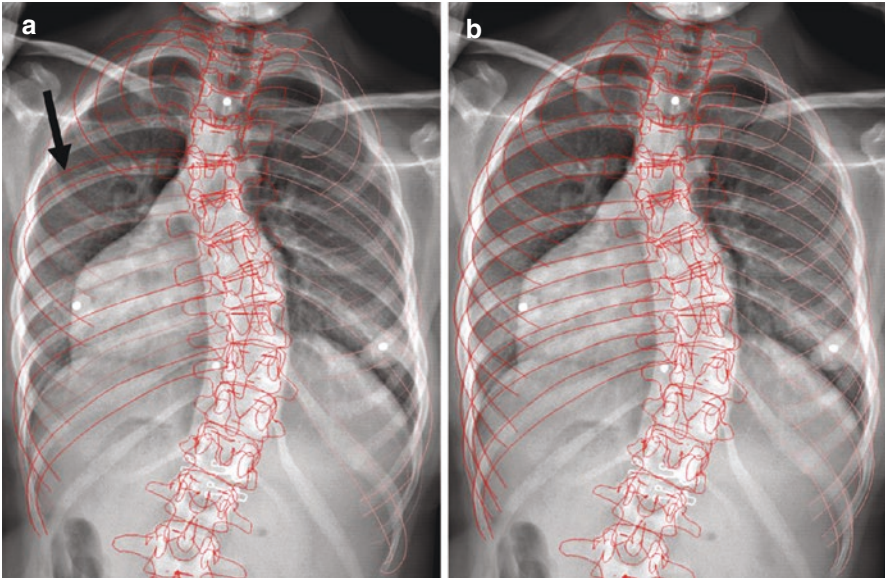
Example of model retroprojection on the real X-rays: (a) the virtual contours (in red) of the initial virtual model does not perfectly match the real contours, (b) final model after adjustments
